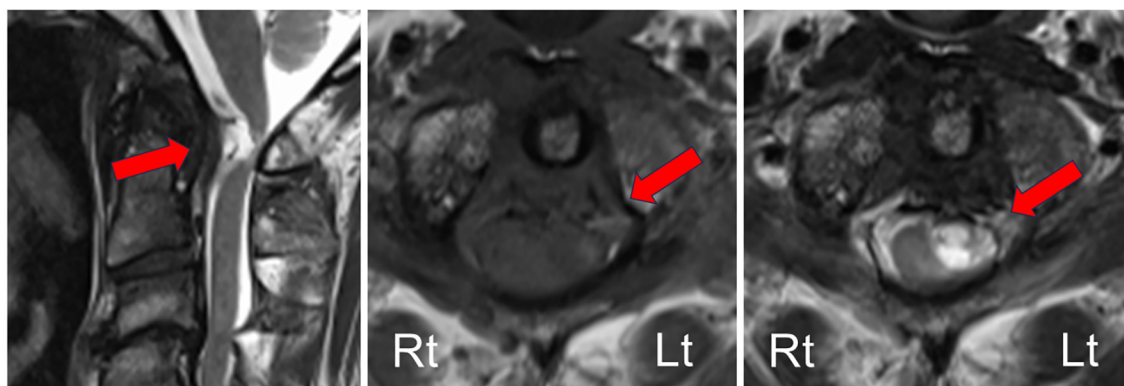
Patient magnetic resonance imaging (MRI) images. Preoperative MRI showed the retro-odontoid pseudotumor (arrow) compressing the cervical medulla. Left: Sagittal T2-weighted image showed a hyperintense mass posterior to the C2 odontoid, causing marked indentation of the cord. Middle: The mass was isointense to spinal cord on T1-weighted MRI. Right: Hyperintense mass on axial T2-weighted image at the C1-C2 level showed that the lesion was compressing the spinal cord.
